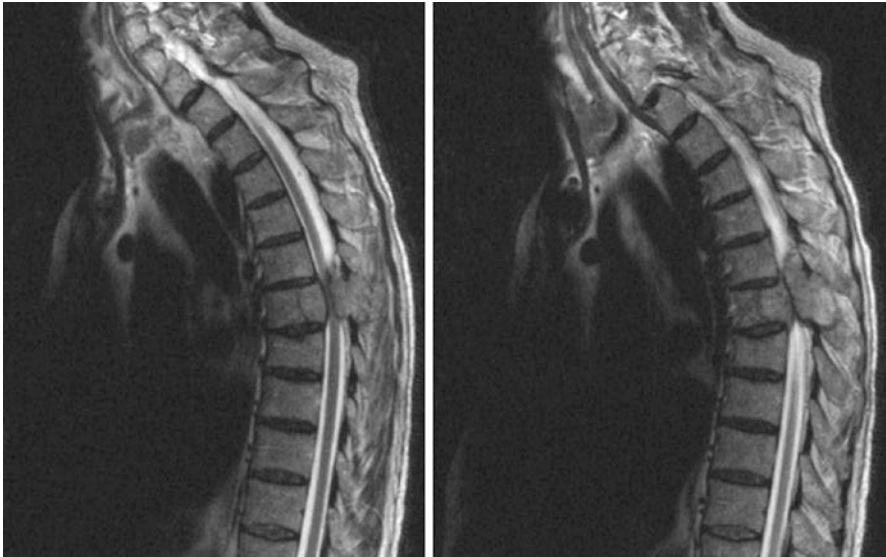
Sagittal T2W MRI of a 60-year-old patient presenting with rapidly progressive paraplegia secondary to an epidural metastatic disease from a renal cell carcinoma
